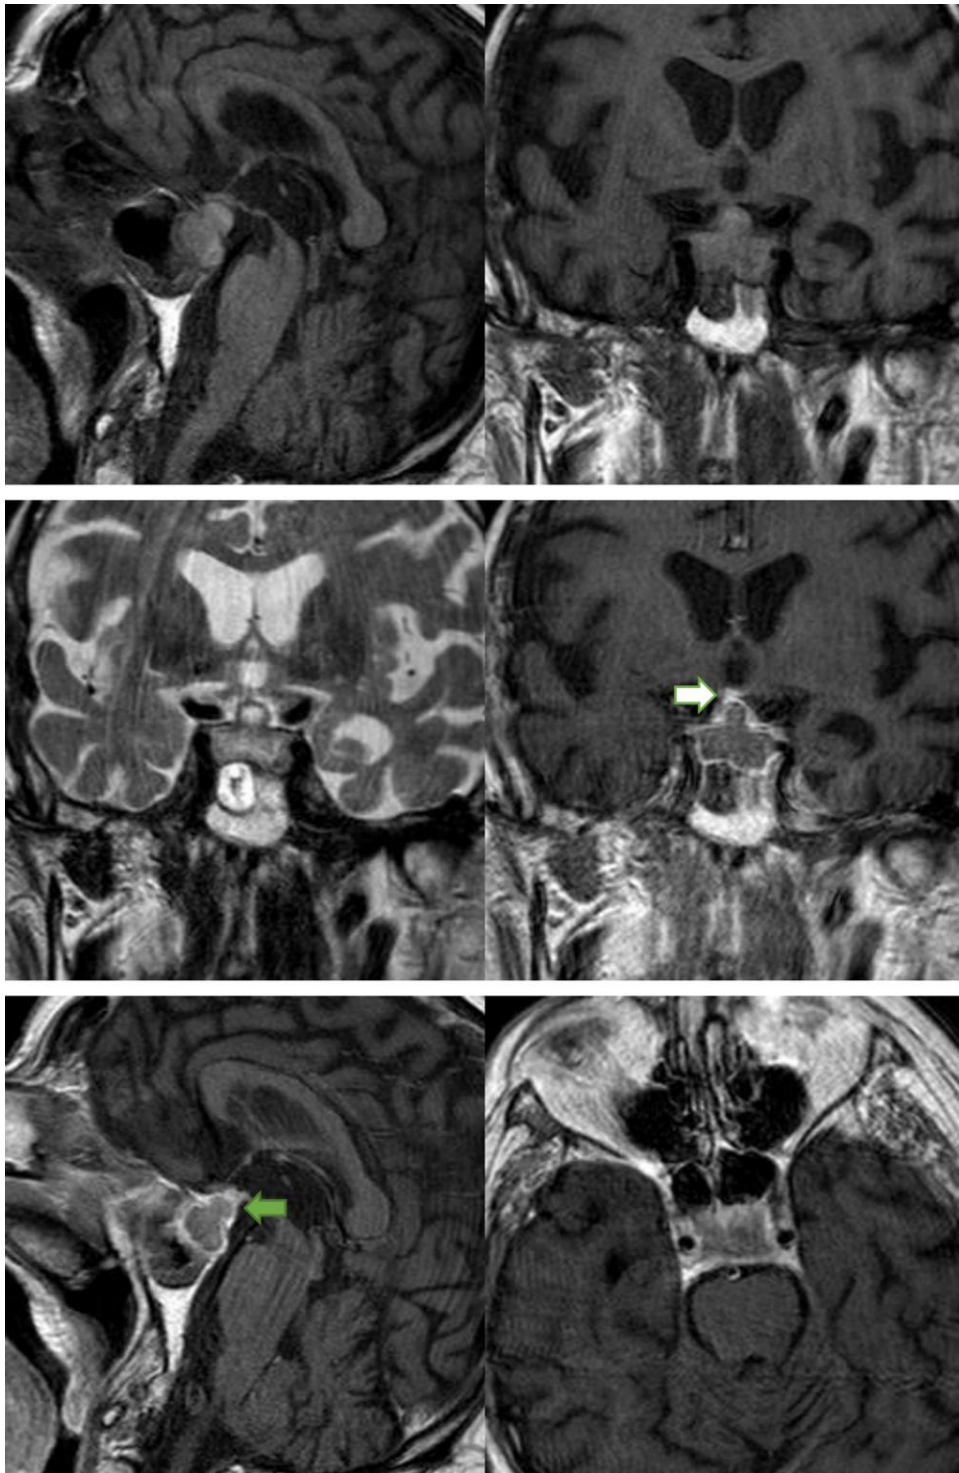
The second magnetic resonance imaging examination revealed a partial improvement with an initial reduction of the thickening of the pituitary stalk (green arrow), infundibulum, and the dura mater; the parasellar T2 dark sign does not appear, and the variation of the intrasellar signal in T1 and T2 weighted images is depicted in the basal sequences.
